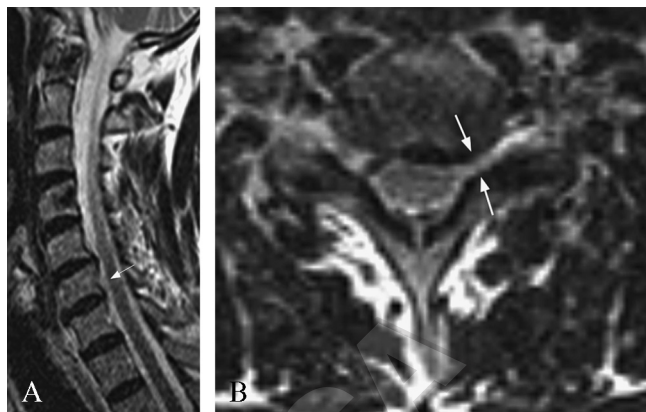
A) Follow-up T2-weighted sagittal image shows complete resorption of the sequestered disc (arrow); B) follow-up T2-weighted axial image after 2 years demonstrates the left paracentral protrusion at the C6-7 level causing narrowing of subarachnoid space and ipsilateral neural foramen (arrow). No compression on spinal cord is observed.
